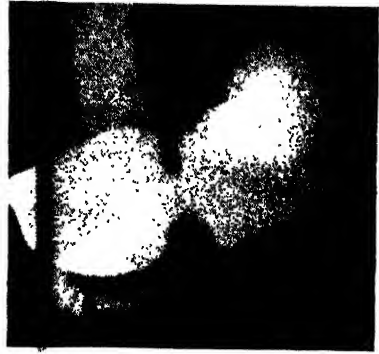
Typical X-ray appearance of pyloric stenosis. Note peristaltic wave in mid-stomach. (Dr. Howard Middlemiss, Bristol.)
